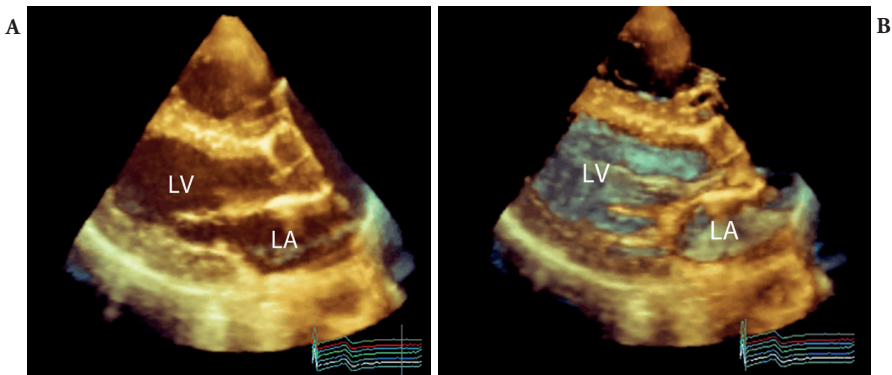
Effect of gain setting on 3D images. (A) Transthoracic PSLAX view of the LV with inappropriately high gain settings. The cavity of the LA and LV is opaque and consequently there is no perception of depth in the image. (B) With appropriate reduction of gain, intracavity noise has been removed and far-field structures can be visualised. In this example, far-field structures are colour coded blue grey and near field brighter and yellow-brown. LV, left ventricle; LA, left atrium
